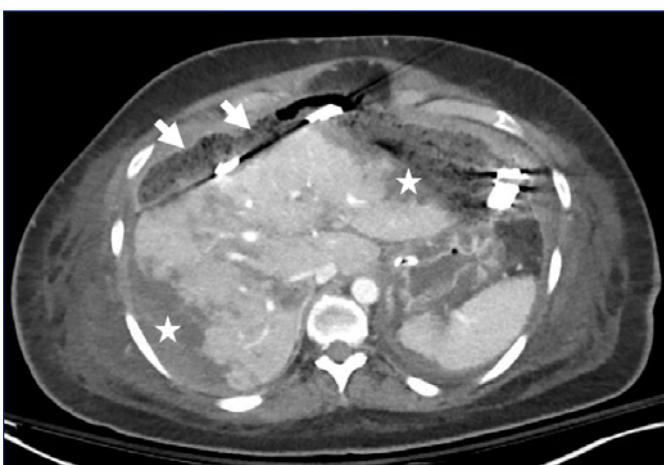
CT angiogram on post-operative day 5 demonstrating diffuse subcapsular hematomas (stars) and packing material (arrows).
